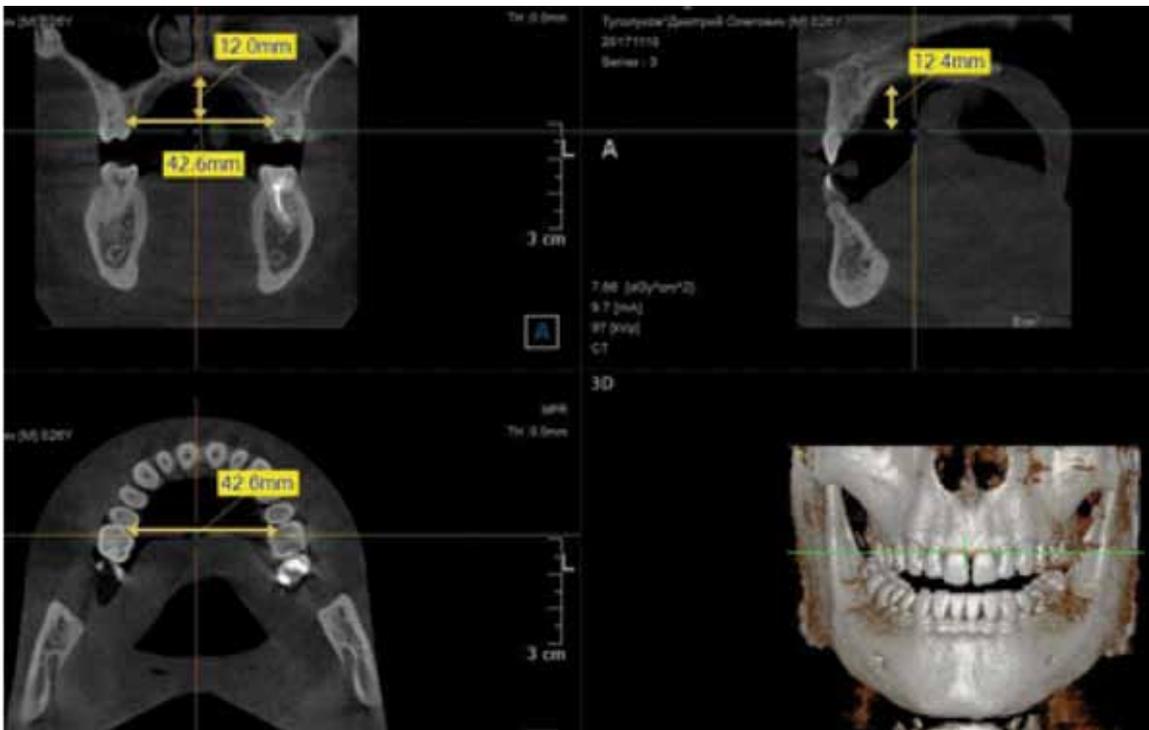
Reference marks for measuring the depth and the width of the hard palate vault on CBCT slices
